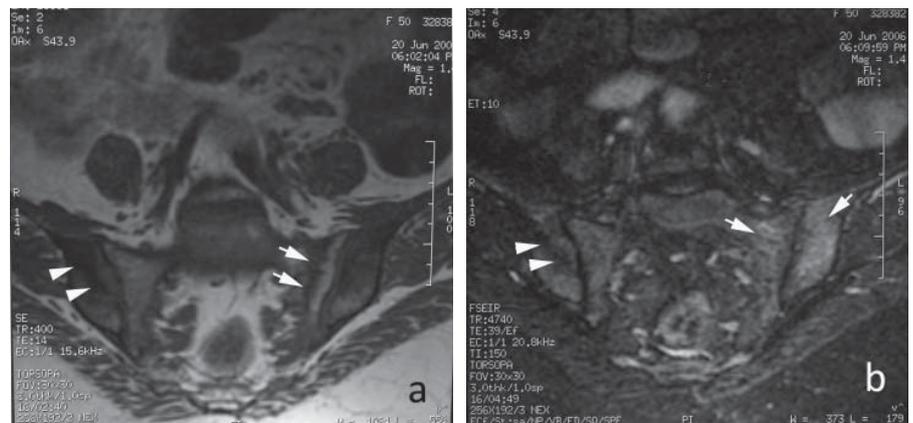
Coronal T1-weighted MR image shows a linear low signal intensity area (a, arrows), with associated bone marrow edema on the left sacral wing and iliac bone on coronal FSEIR image (b, arrows), which were found to be concordant with stress fractures. There is also a low signal intensity line without accompanying bone marrow edema on the right iliac wing (arrow heads on a and b) consistent of with healed old fracture.
